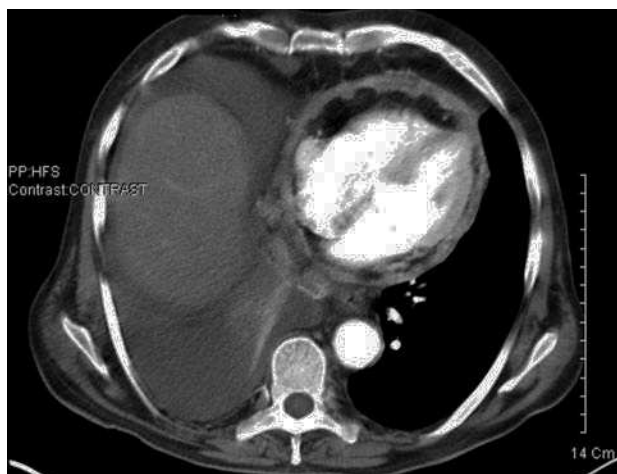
A chest computed tomography scan showing irregular circumferential thickening of the pericardium with no effusion, indicative of constrictive pericarditis. Right pleural effusion is also visible.
